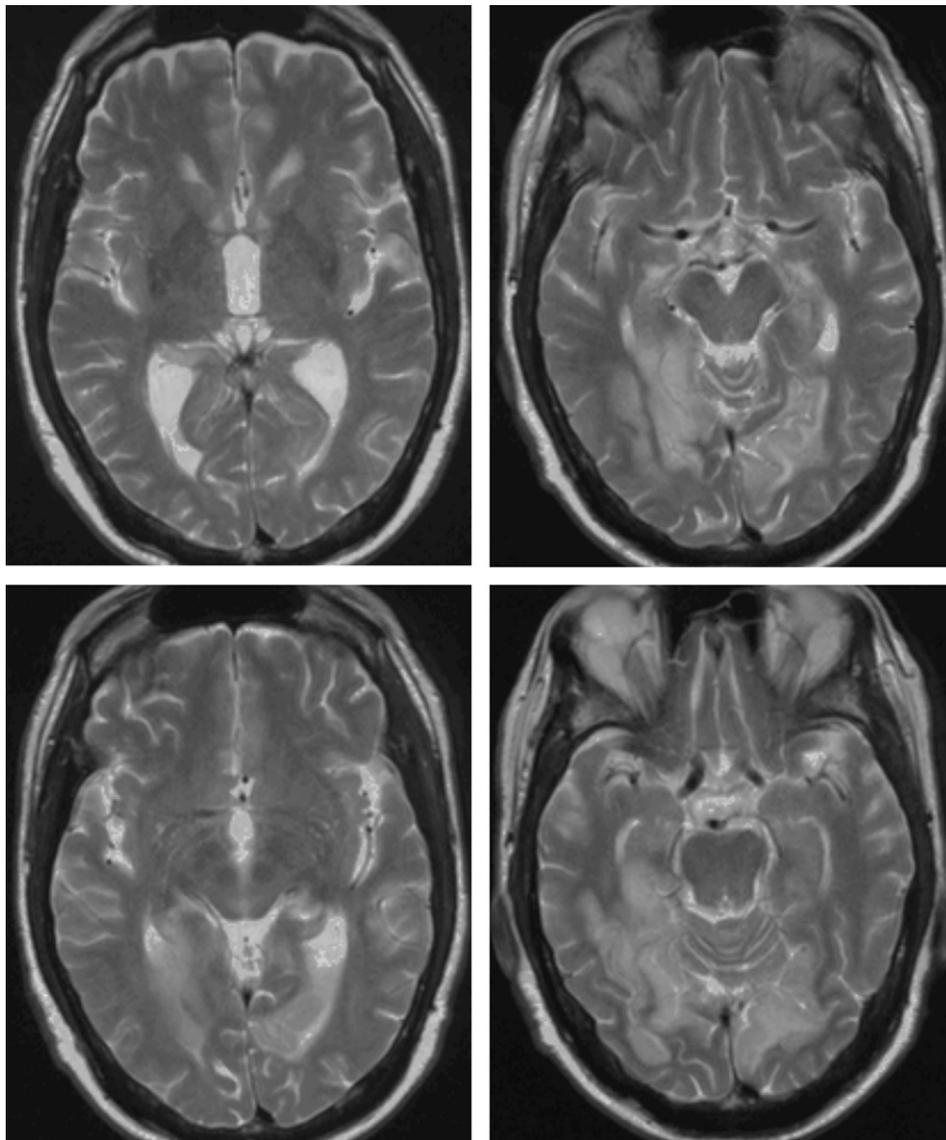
Axial T2-weighted MRI scan slices of the patient two days after the stroke. Hyperintense lesions are noticeable in the distribution of both posterior cerebral arteries involving the fusiform gyri, lingual gyri, and parahippocampal gyri.
